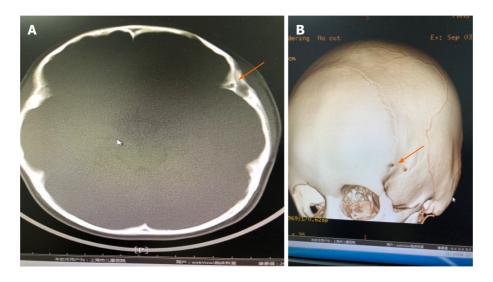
Computed tomography and three-dimensional imaging of the left frontotemporal. A: Computed tomography (CT) images. At the left frontotemporal junction, an irregular low-density mass with a size of about 15.28 mm × 14.16 mm was observed subcutaneously, and the density was uneven. The CT value was about 32 HU. After enhancement, the edge of the lesion was enhanced, and the CT value was about 61 HU in the arterial phase and 86 HU in the venous phase. The local tubular foci extended to the deep left frontal temporal bone, which seemed to penetrate the inner plate of the skull. Osteosclerosis was visible in the marginal bone. The boundary between the lesion and adjacent muscles was not clear, and local skin become thick with abnormal enhancement changes; B: Three-dimensional imaging. Orange arrows indicate the fistula.
